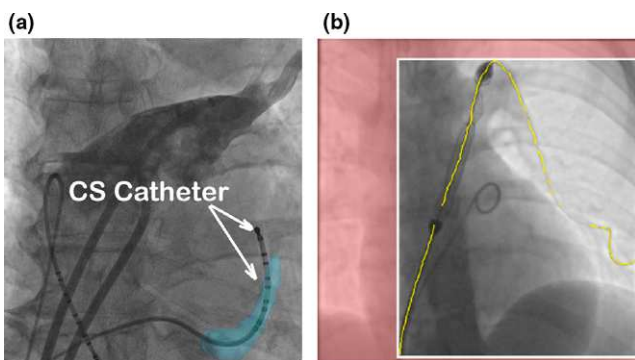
(a) Aligning the CS model (light blue color) with the CS catheter in the X-ray image for 2D to 3D registration. (b) Localized guidewires are shown in yellow. The predicted collimation box is shown with white boundaries with the area outside set to red. [Color figure can be viewed at wileyonlinelibrary.com]
